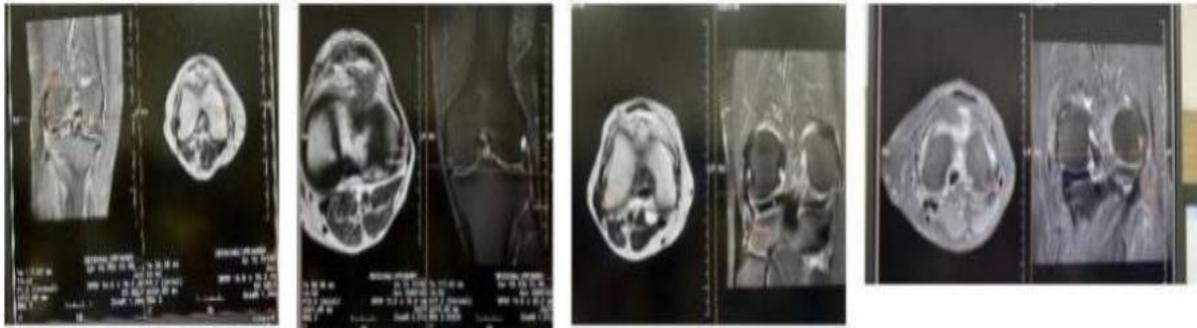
Representative MRI images of the knee from the study cohort, demonstrating various planes used for the radiological analysis of the anterolateral ligament
